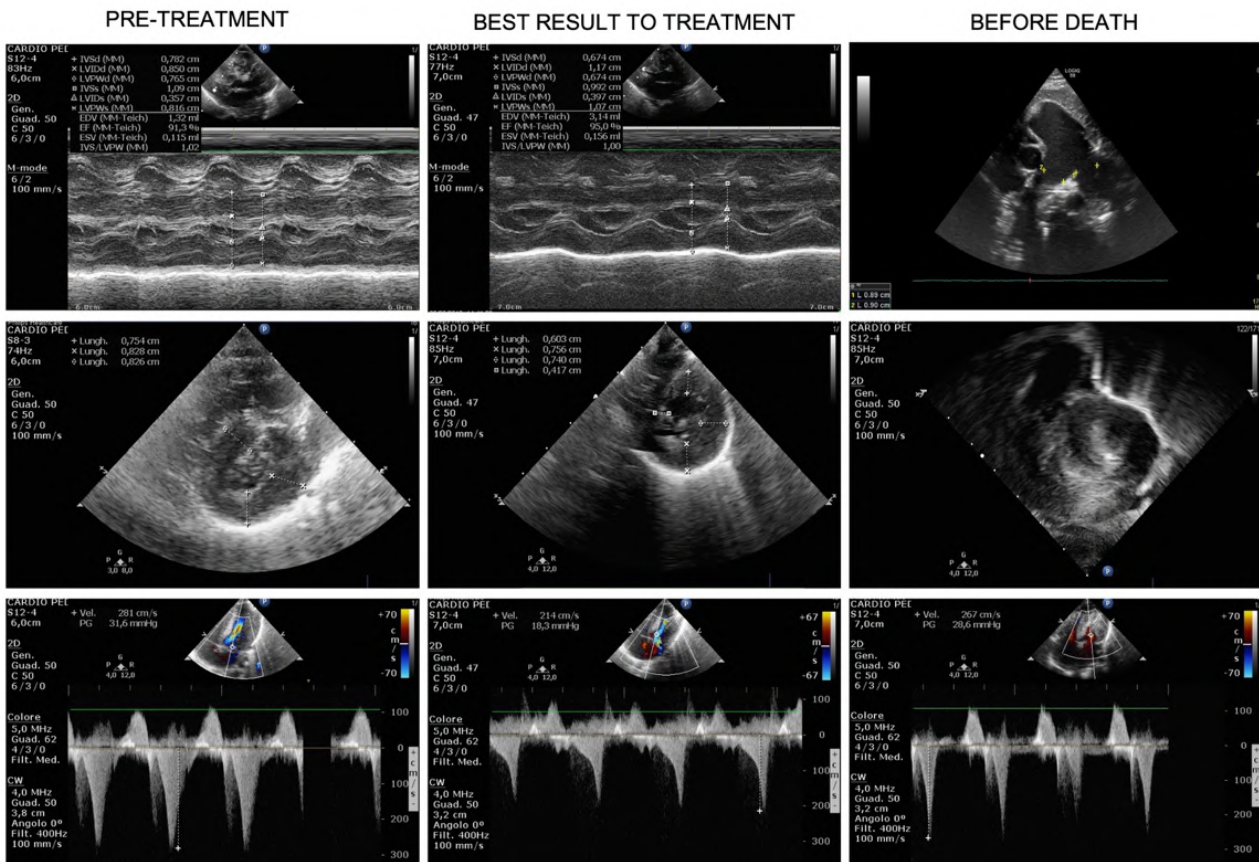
Evolution over time of hypertrophic cardiomyopathy (HCM). Pre-treatment US (first column) shows severe HCM at M-mode Left Ventricle (Mm-LV, first row), short-axis LV (second row) and LV outflow track obstruction (CW-Doppler, third row), few days before treatment start. The
